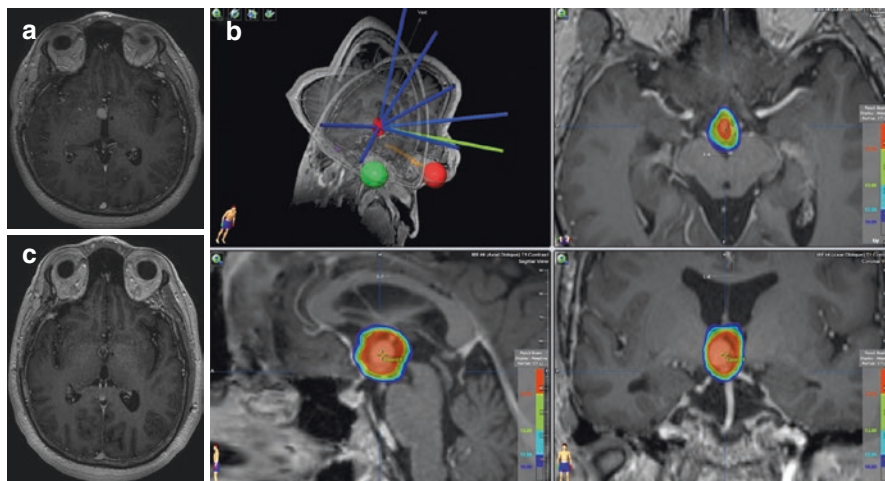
Craniopharyngioma. (a) MRI before SRS. (b) Treatment plan SRS, Dose prescription 15 Gy periphery. (c) MRI 1 year follow up
